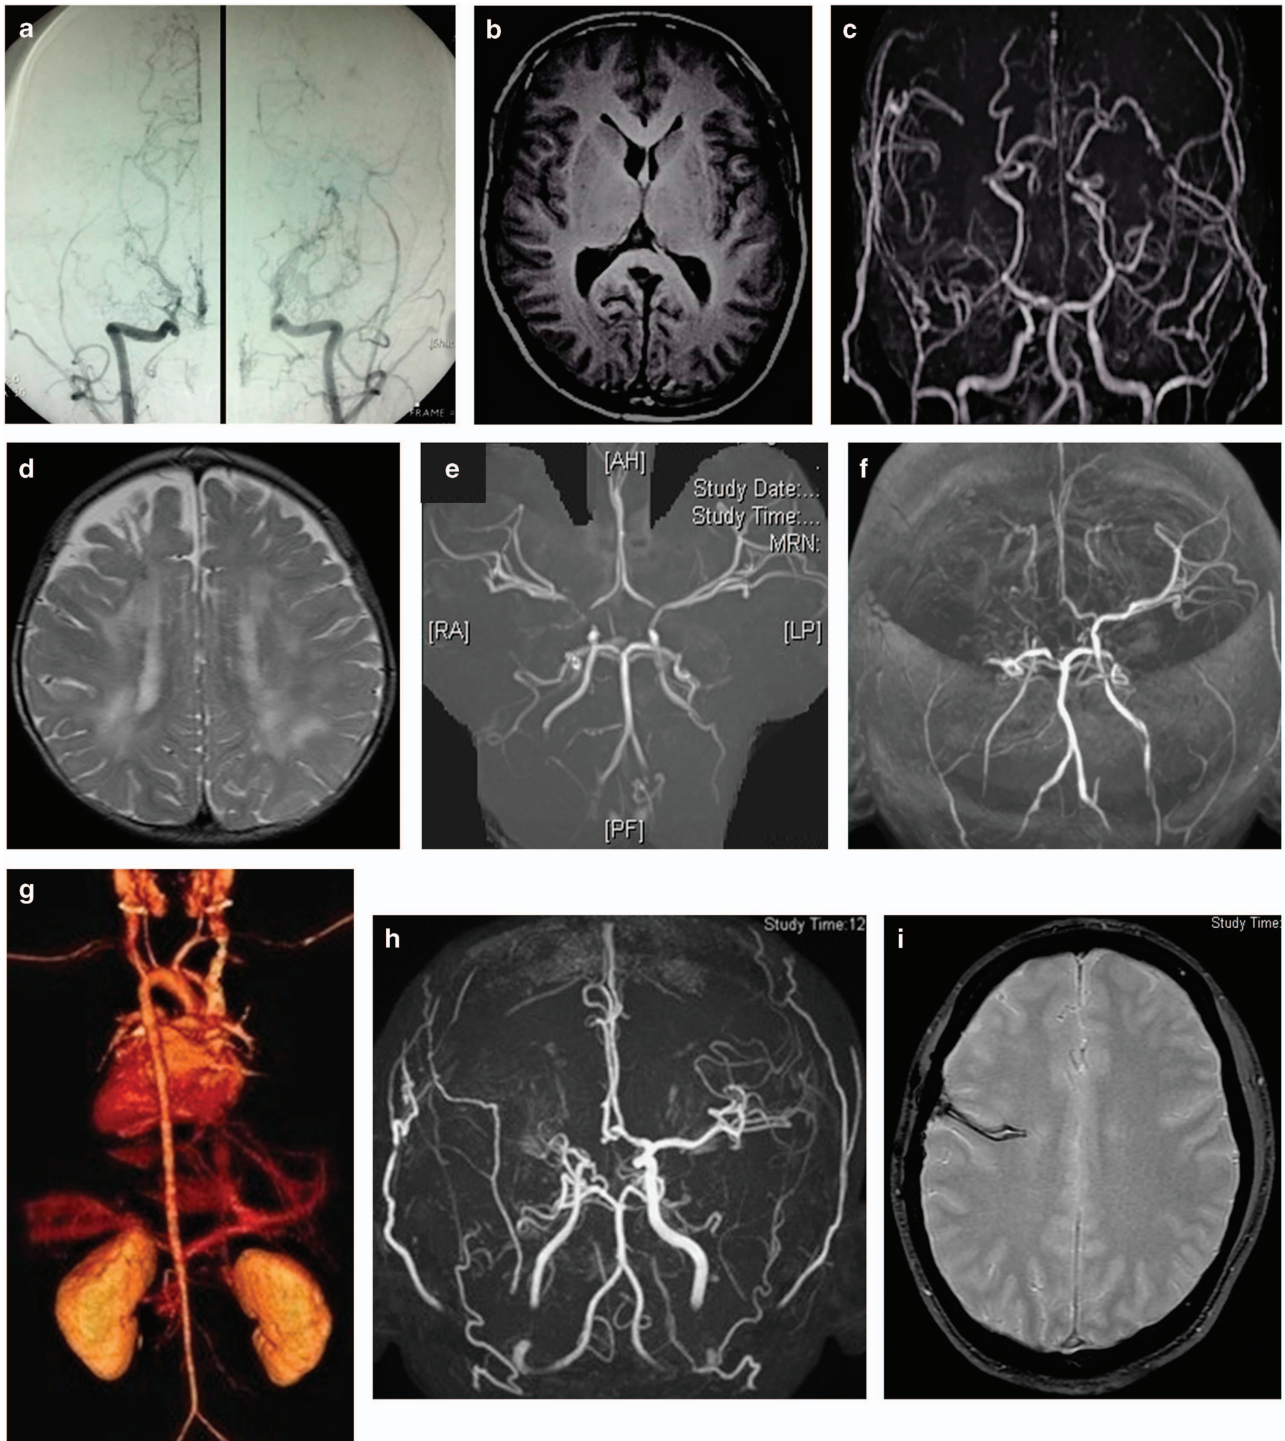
Radiological studies of the patients. Conventional angiography of the first patient shows bilateral stenocclusive changes of the ICAs with moyamoya vascular networks (a), which are also indicated by low-signal-intensity flow voids in the bilateral basal ganglia in T1-weighted magnetic resonance imaging (MRI) (b). Post-operative magnetic resonance angiography (MRA) shows bilateral bypasses between the superficial temporal arteries and the middle cerebral arteries (c). T2-weighted MRI of the second patient shows bilateral cerebral infarctions (d). MRA shows bilateral stenosis of the ICA terminals, which is more severe on the right side (e). MRA 4 years after surgery shows stenoses in the right vertebral artery and the proximal portion of the left ICA, in addition to the disease progression on the right side (f). Three-dimensional-computed tomography angiography (3D-CTA) shows diffuse stenosis along the descending aorta involving the left renal artery (g). MRA shows a stenocclusive change at the right ICA terminal with moyamoya vascular networks (h). T2*-weighted MRI of the third patient shows a low-signal-intensity hemorrhagic scar in the right frontal lobe (i).
